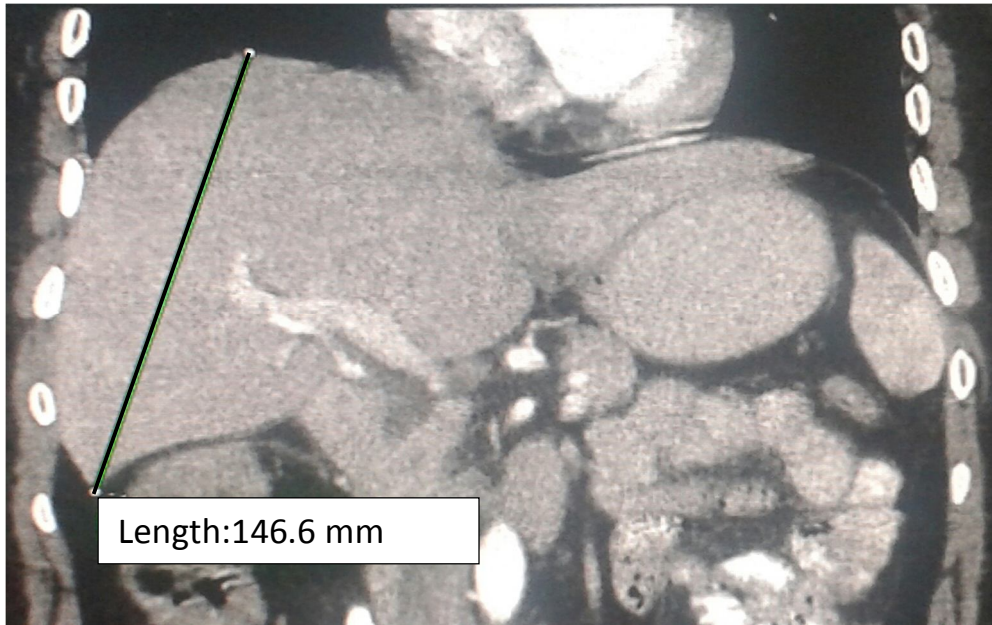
Coronal CT image for male (60 years) show measurements of maximum craniocaudad.
